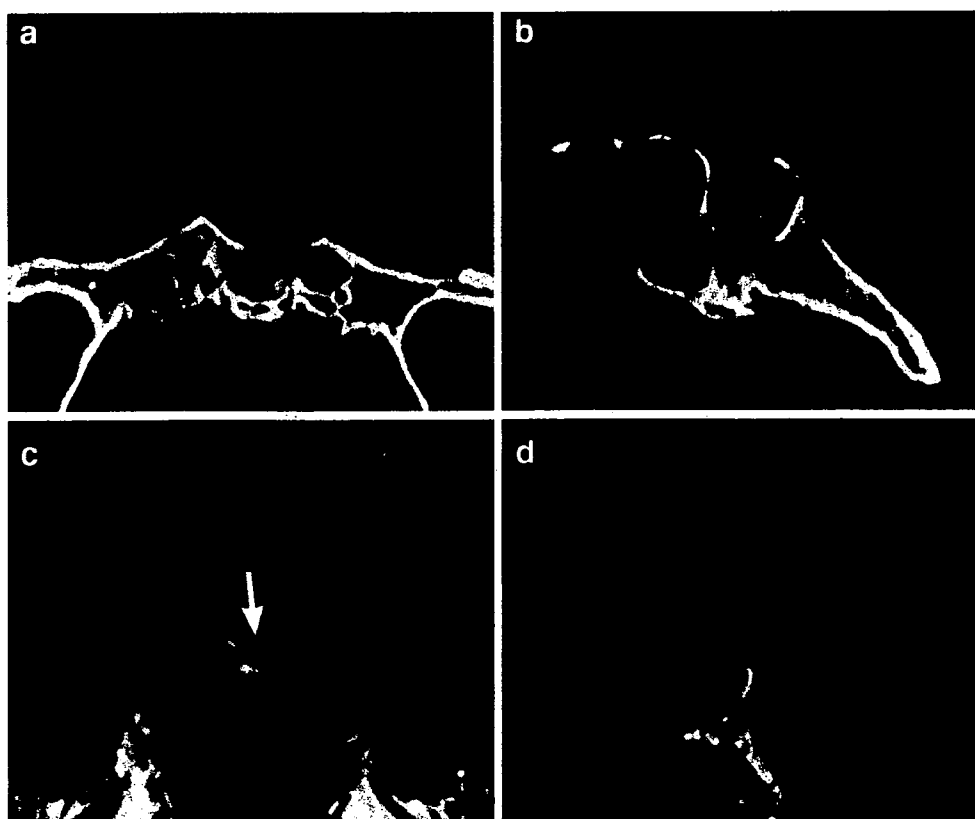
Growth hormone-producing pituitary adenoma eroding the floor of the sella turcica and invading the sphenoid sinus and clivus. Coronal and sagittal bone window reconstructed MDCT images (score 2) (a, b) demonstrate destruction of the sellar floor better than coronal and sagittal spin-echo T1-weighted MR images (score 1) (c, d) (*arrows*)
